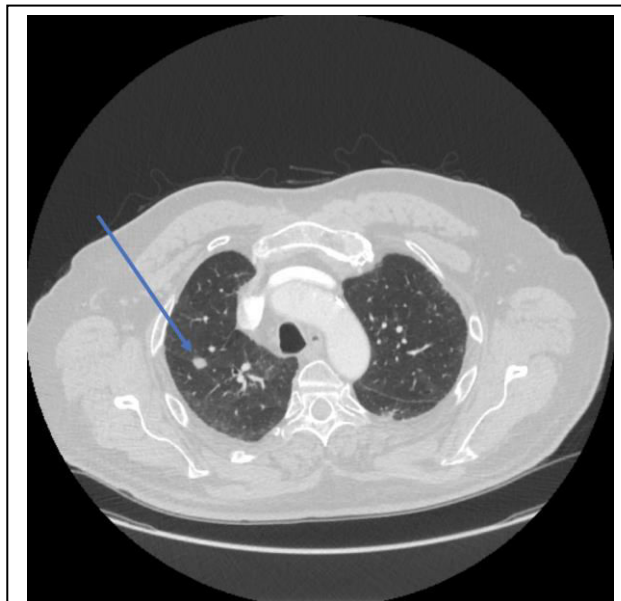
Follow-up CT image showing the largest dimensions measuring 12 mm.
